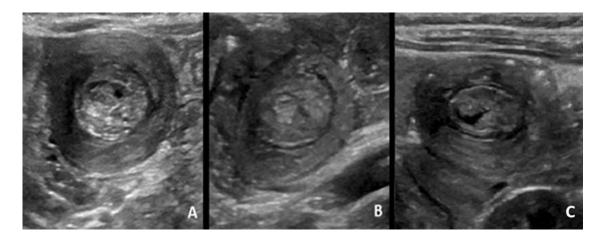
Ultrasounds of the left upper quadrant of the abdomen transverse to the axis of the bowel showing a target sign indicating intussusception. (A) Before first surgery. (B) Before second surgery. (C) One week after second surgery when patient was clinically asymptomatic.
